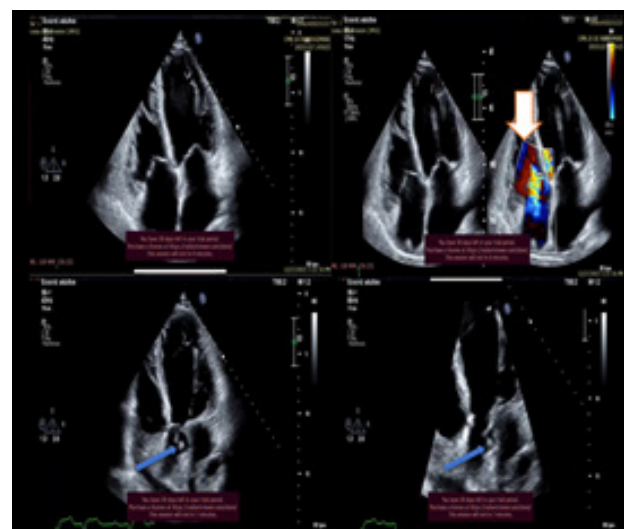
The transesophageal echocardiography (TEE) image with a four-chamber apical axis
